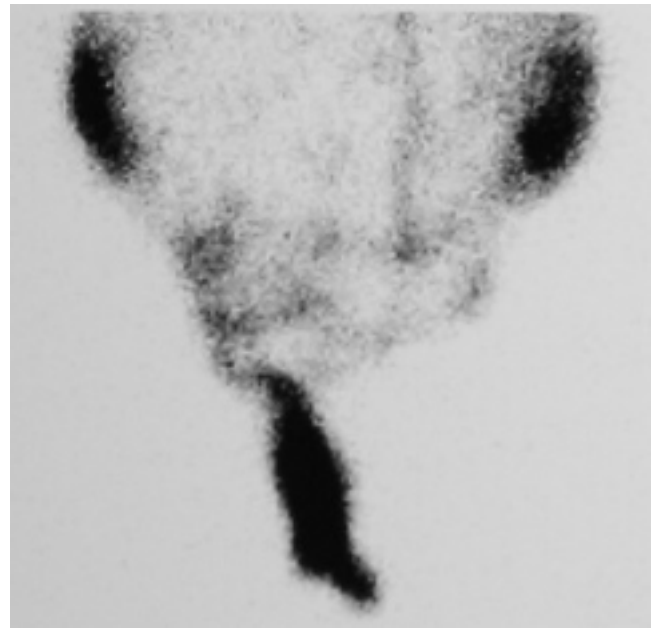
Peritoneal scintigraphy post-drain image demonstrating right inguino-scrotal fluid collection.
